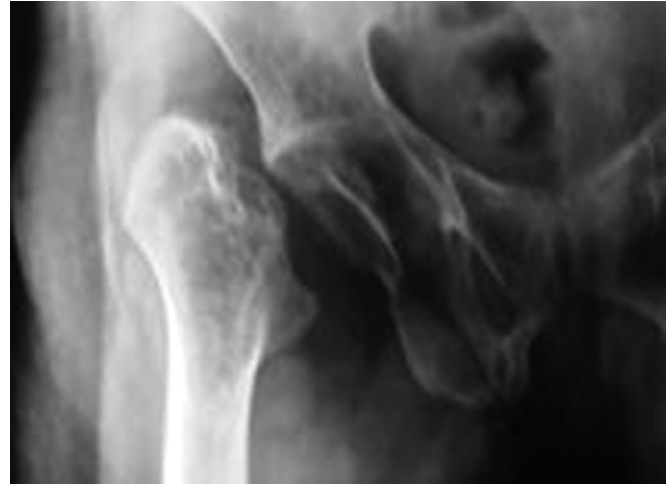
X-ray pelvis with both hip joints AP view showing Girdlestone arthroplasty on right side.
